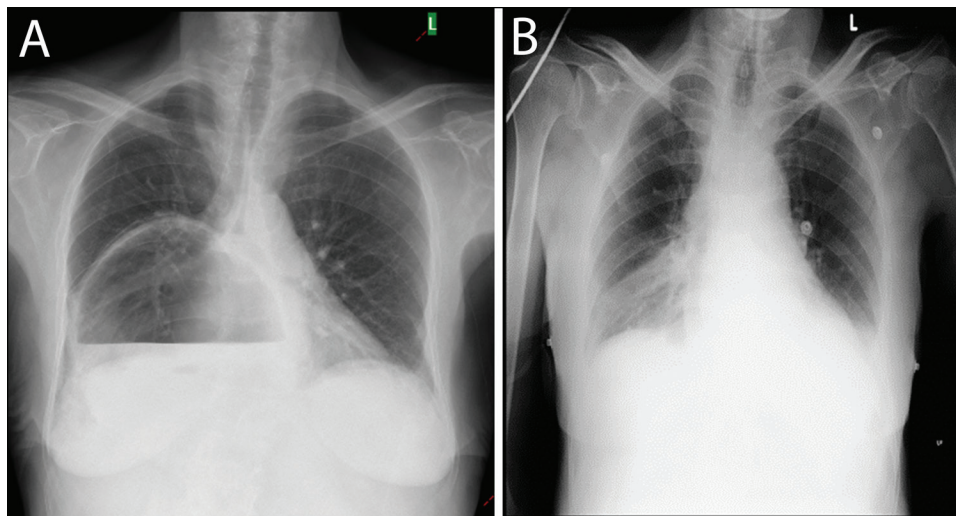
(A) Preoperative chest X-ray showing a large air-fluid level occupying the right hemithorax. (B) Post-operative normal chest X-ray following successful repair
